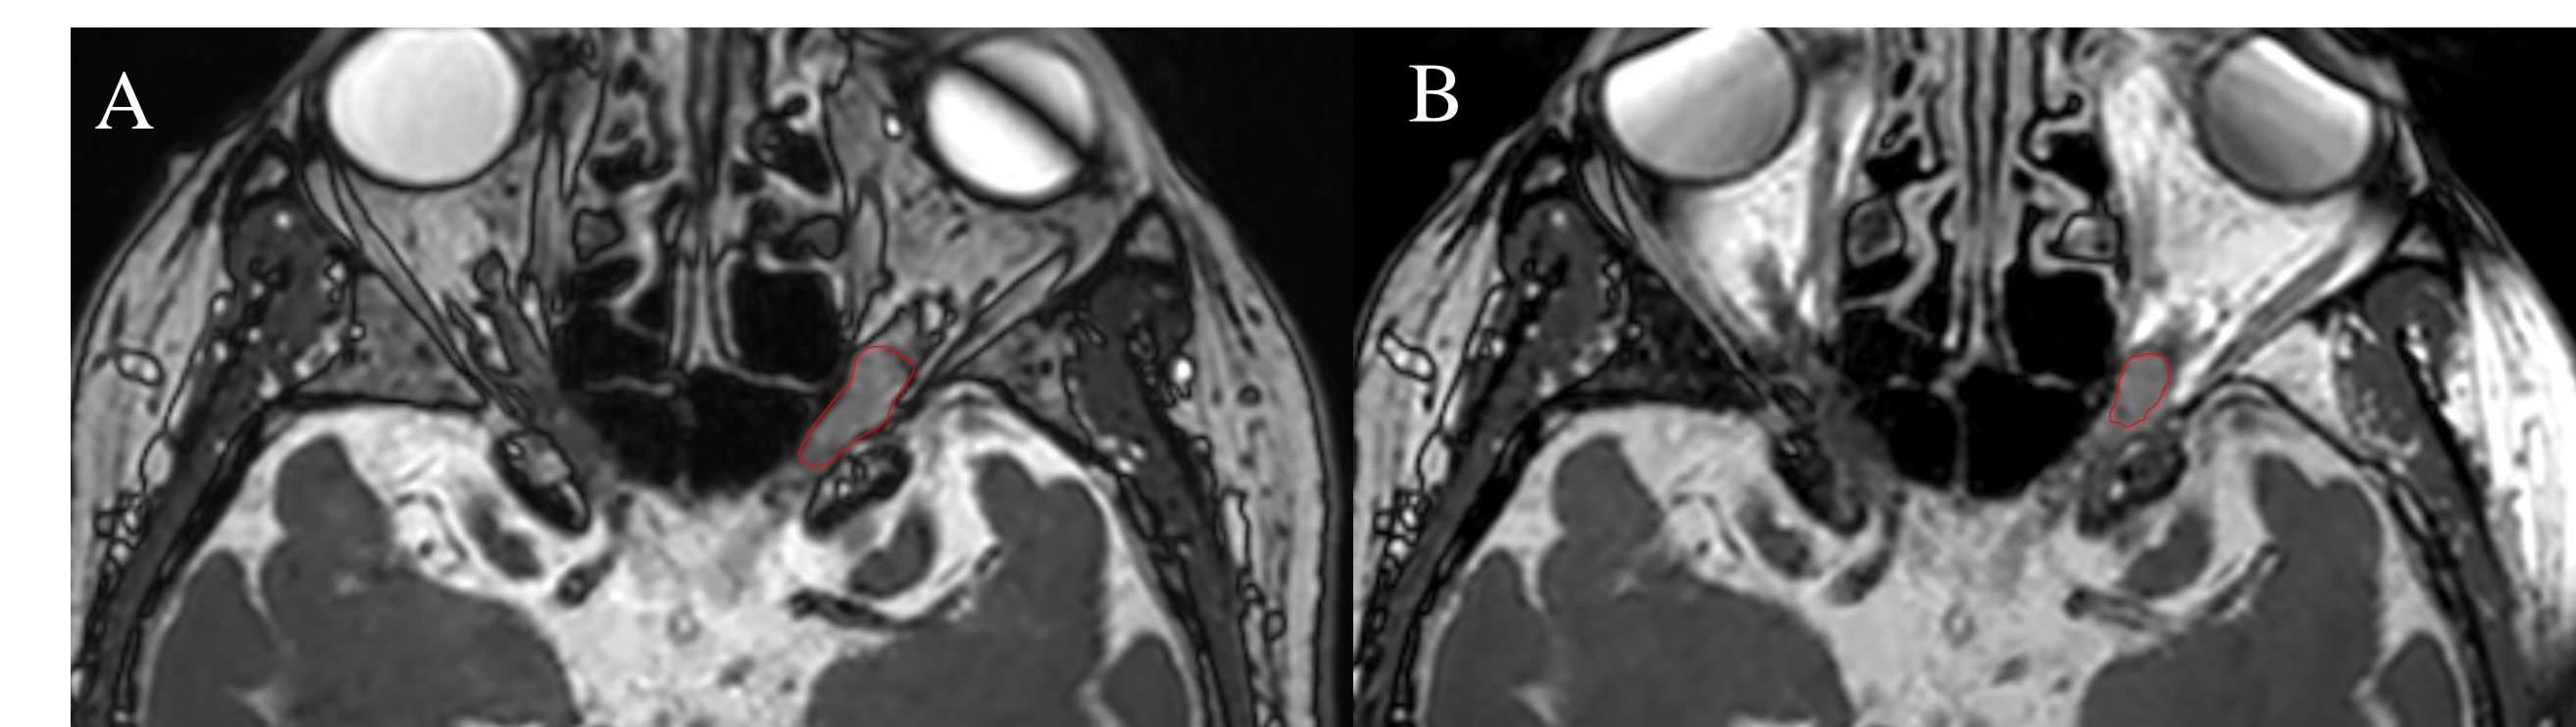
MRI Comparison of (A) pre-SRS and (B) six-months post-SRS.
